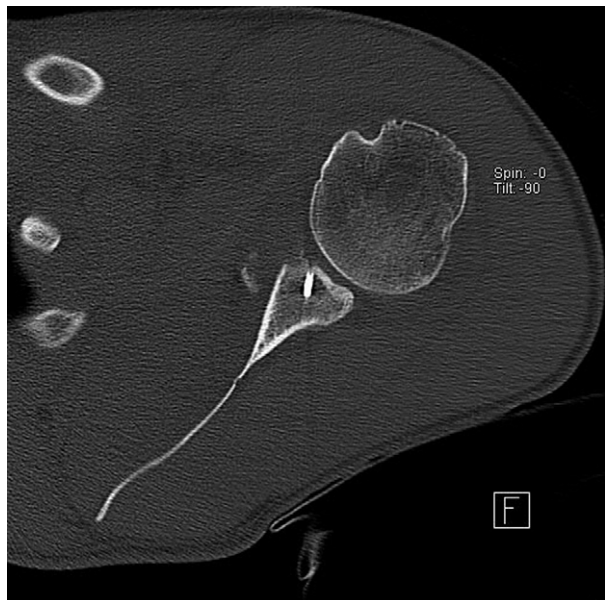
Axial computed tomography scan showing fracture of glenoid rim distal to a well-fixed anchor in a patient who had a shoulder dislocation while skiing after prior successful arthroscopic stabilization.
